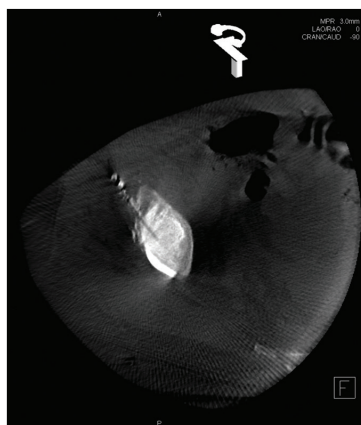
A postprocedural cone-beam CT scan showing cement placement in the right superior acetabulum.
